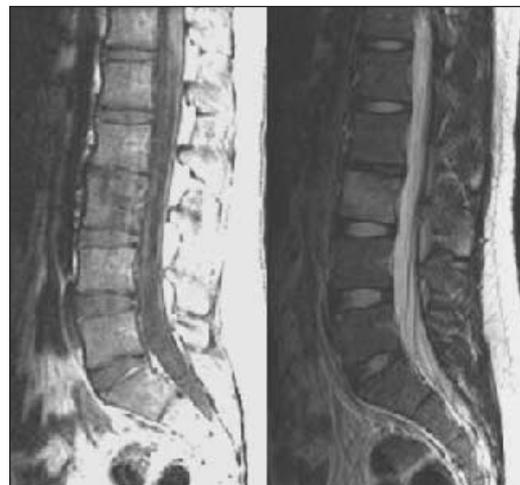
Follow up MRI 1 month after treatment showed slow resolution of disc and bone edema
